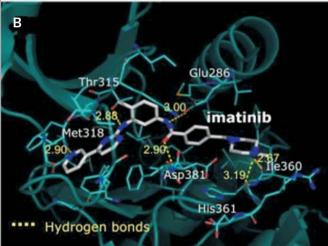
X-ray structures of bafetinib/ABL (A) and imatinib/ABL complexes (B). Adapted from Horio, T., Hamasaki, T., Inoue, T., Wakayama, T., Itou, S., Naito, H., Asaki, T., Hayase, H., Niwa, T. *Structural factors contributing to the Abl/Lyn dual inhibitory activity of 3-substituted benzamide derivatives*. Bioorg Med Chem Lett 2007, 17(10): 2712-7, with permission from Elsevier.
